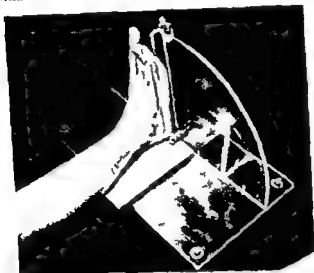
Device used in the roentgen examination of an ankle injury
